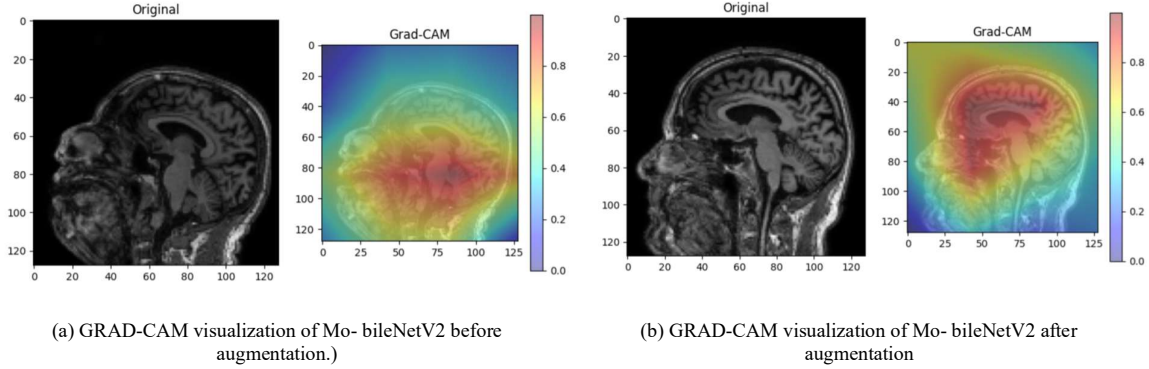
Grad-CAM visualizations highlighting model attention in MRI scans
